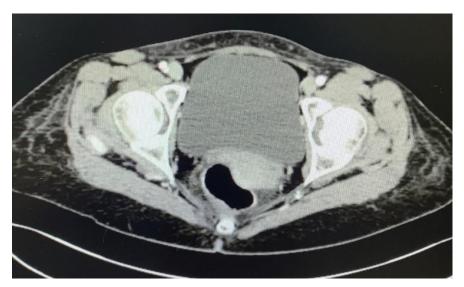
Pelvic CT scan showing a tumor in the utero-vesical recess of maximum 7/10 mm
